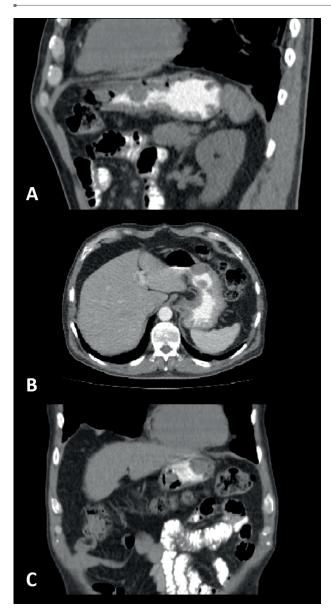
Standard abdominal computed tomography, with solid polypoid gastric lesions. (A) Sagittal cut. (B) Axial cut. (C) Coronal cut.
